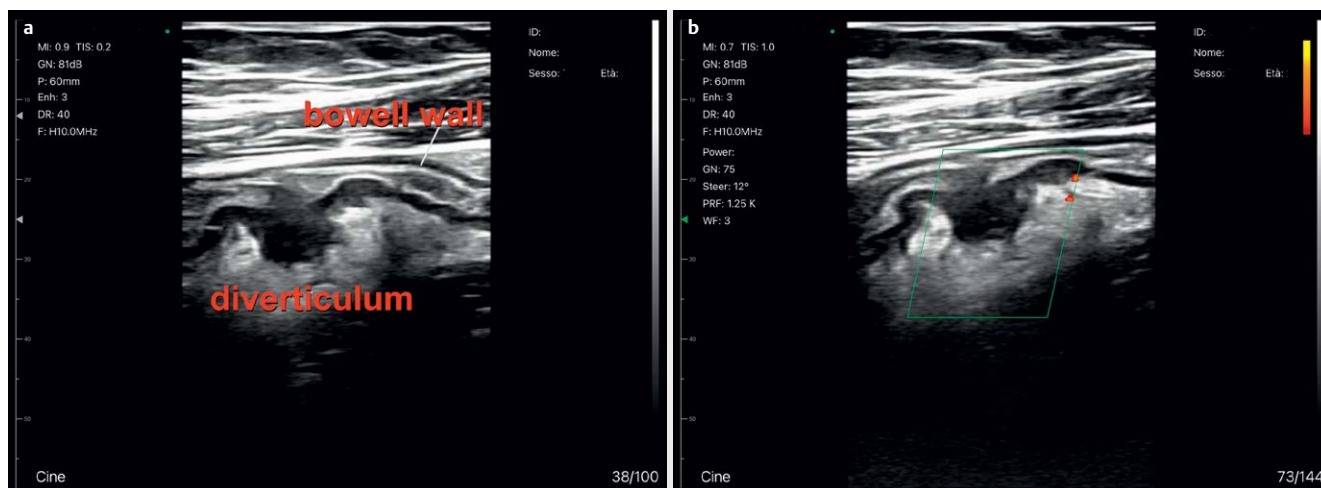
A case of confirmation diagnosis: 78-year-old man is hospitalized for pain in the left iliac fossa and fever; abdominal examination shows severe pain on deep palpation in the left iliac fossa; palmar ultrasound demonstrates (a) the presence of outpouring of the sigmoid wall, with its thickening, thickening of the mesentery; on power Doppler (b) presence of flow inside the mesentery, near the diverticulum, a sign of acute inflammation.
